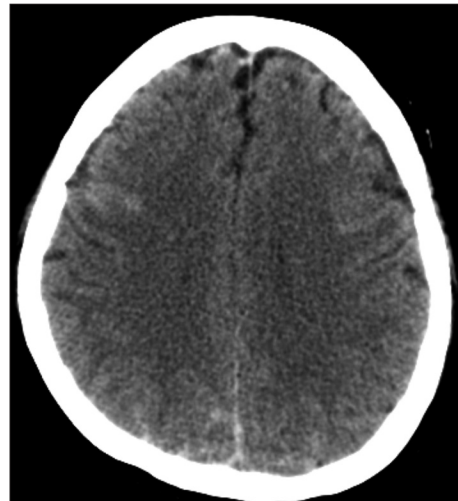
CT image showing SAH in both parietal portions. SAH : spinal subarachnoid hemorrhages.
